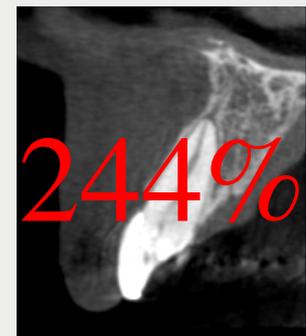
Cone beam computer tomography: tooth 21.
